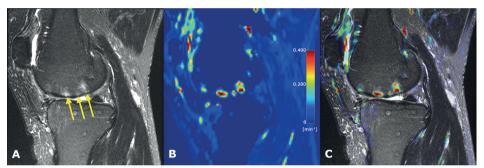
Examples of T2 and DCE-MRI. Sagittal T2-weighted MR image with fat saturation of an osteoarthritic knee showing BMLs in the subchondral bone of the femur (arrows) (A), Ktrans perfusion map of same region shows increased perfusion in the BMLs compared to surrounding bone (B) and T2 and perfusion images fused (C).
